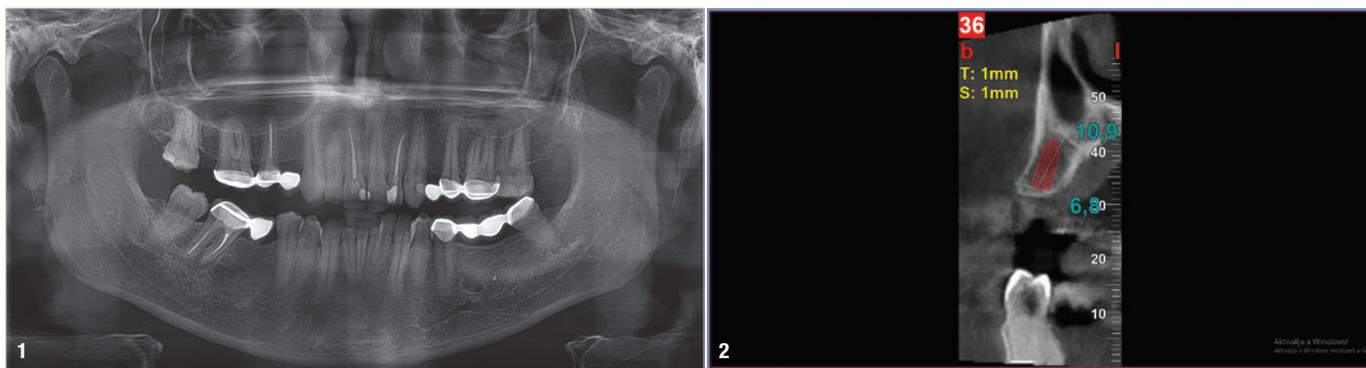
Pre-op dental panoramic tomogram showing missing maxillary right first premolar and cantilever bridge. Fig. 2: Digital planning with CBCT for implant size.
